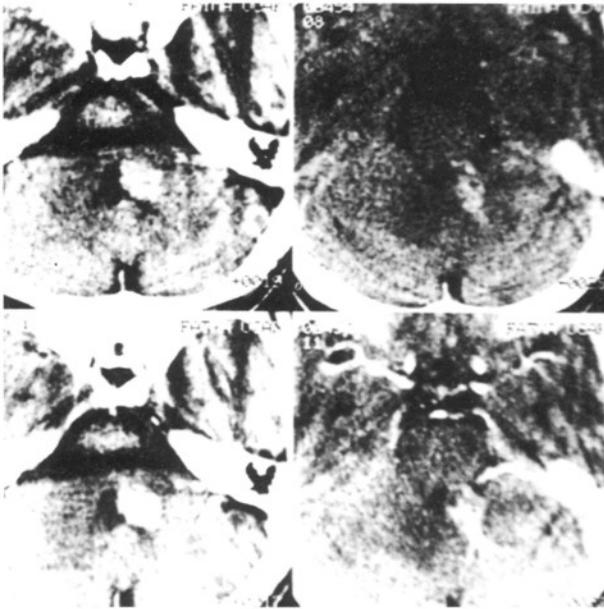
Postcontrast CT scan showing a hyperdense contrast enhancing mass on the left wall of the fourth ventricle and a vascular structure having caput-like appearance.
